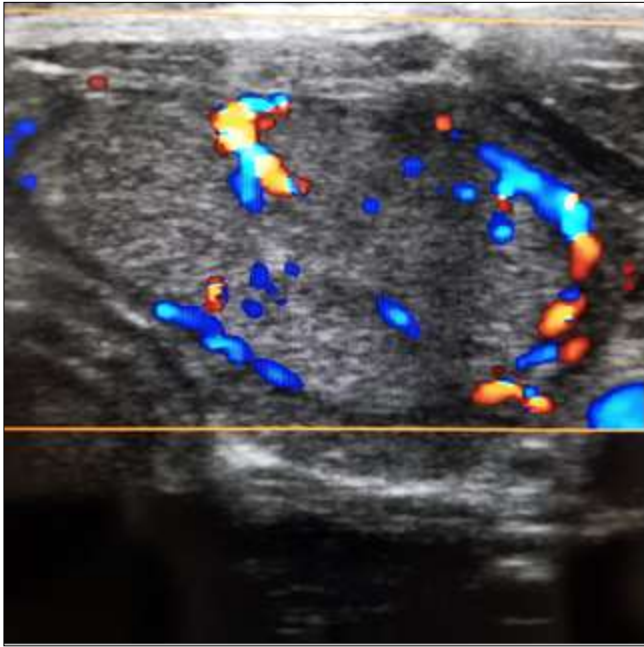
Transverse axis doppler ultrasound image through the left thyroid lobe shows increased vascularity within the nodule
